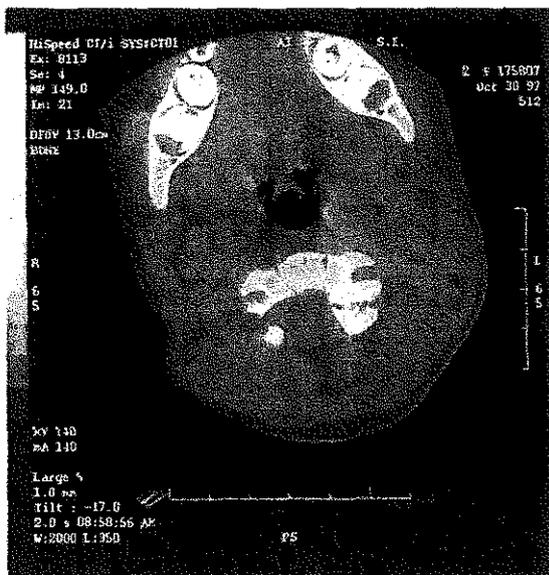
Initial CT scan, C2 level, confirming bilateral pedicle defects with smooth margins. Differential diagnosis included primary spondylolysis vs Hangman's fracture
